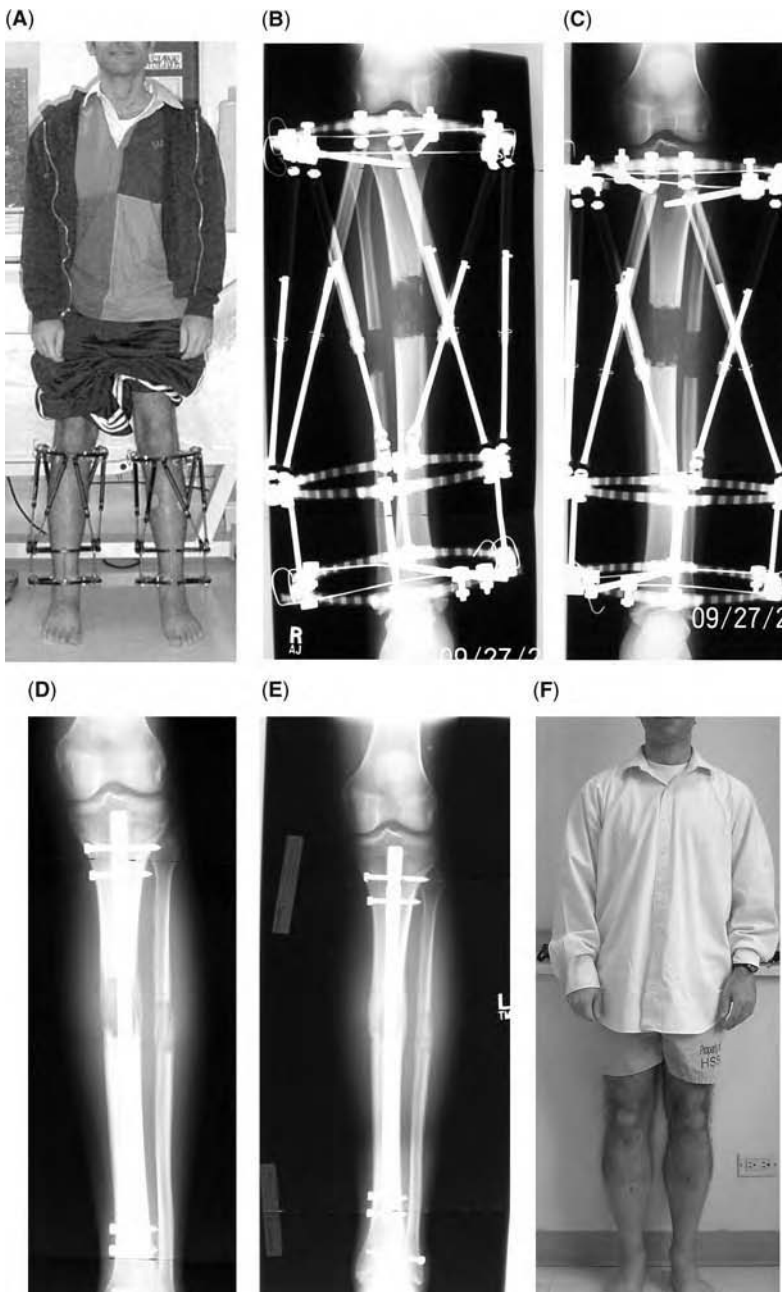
Case example of a 5 cm stature lengthening using lengthening and then nailing of the tibia. (A) Front standing view two months after surgery. (B and C) Anteroposterior (AP) radiographs of both legs showing 5 cm of distraction. (D) AP radiograph of left tibia two weeks after intramedullary (IM) nailing. Note oblique syndesmosis screw. (E) AP radiograph of left tibia two months after IM nailing. (F–H) Clinical photos four months after IM nailing and six months after initial surgery. (I–L) AP and lateral radiographs of both legs four months after IM nailing and six months after initial surgery. Note the absence of the syndesmosis screws.
